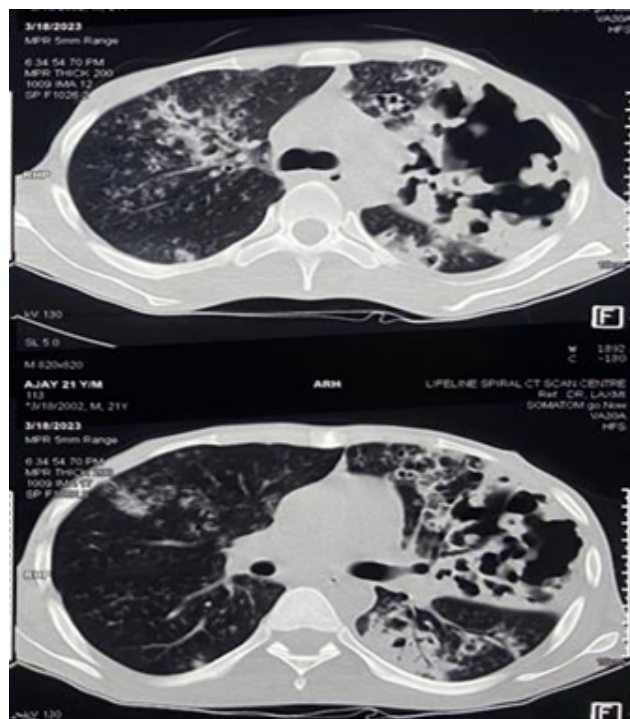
CT thorax showing necrotizing pneumonia, tree-in-bud appearance and bronchiectasis.
